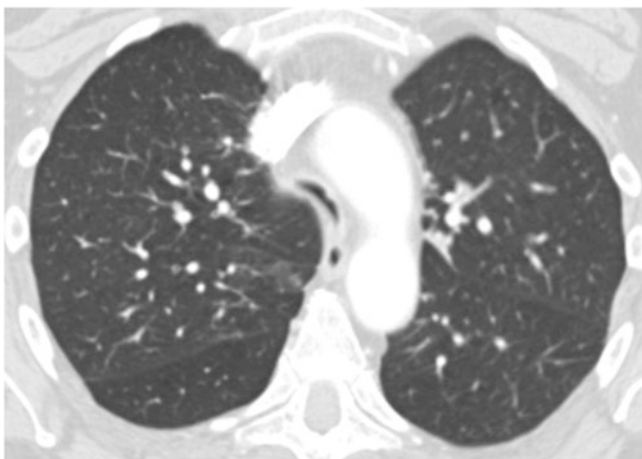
A CT scan of the chest of a 57-year-old man with severe tracheomalacia demonstrating the “frown sign”
